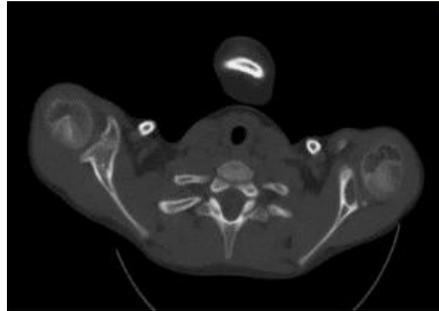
CT scan of skull, neck, thorax, abdomen and pelvis with intravenous contrast, bone window, August 2023
